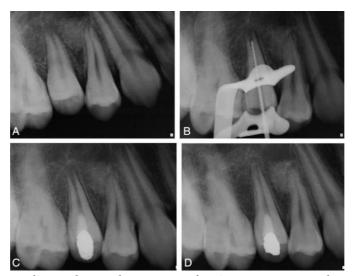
(A) Preoperative radiograph reveals presence of an immature root and an open apex in the second maxillary premolar tooth. (B) A large file is used to determine the root length radiographically. (C) Tooth is double-sealed with Cavit and amalgam. (D) Radiographic examination of the patient 5 1/2 months later shows resolution of periapical lesion, further root development, and continued apical closure of root apex in second maxillary premolar tooth.
